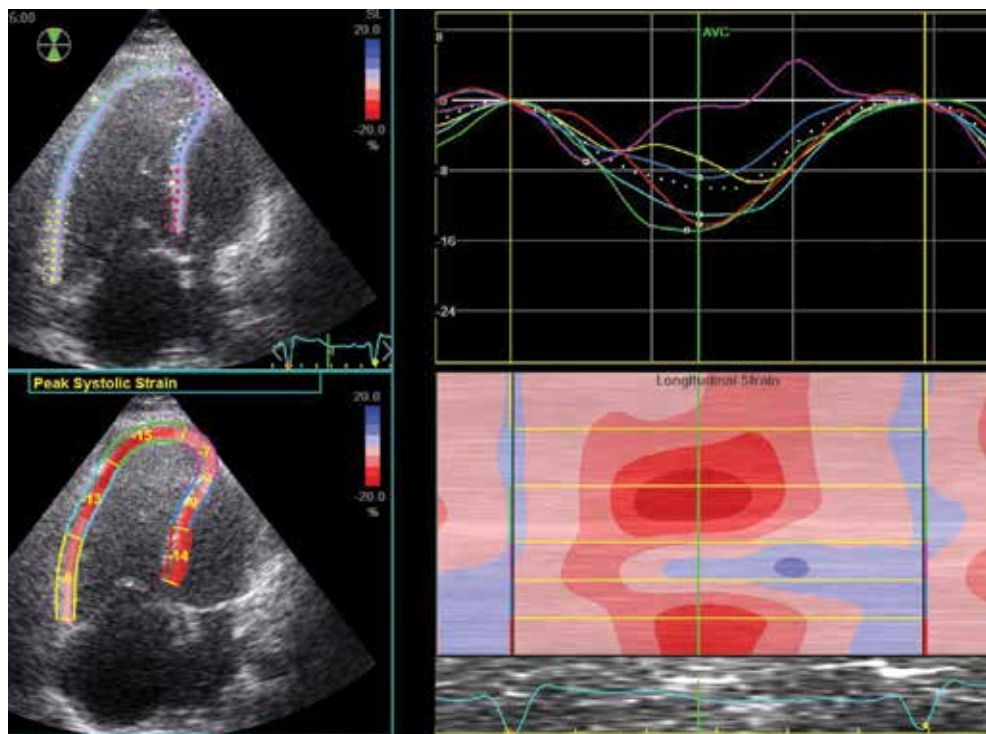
Showing RV free wall strain averaged over the three segments of the RV free wall in RV-focused apical four-chamber view (%)
